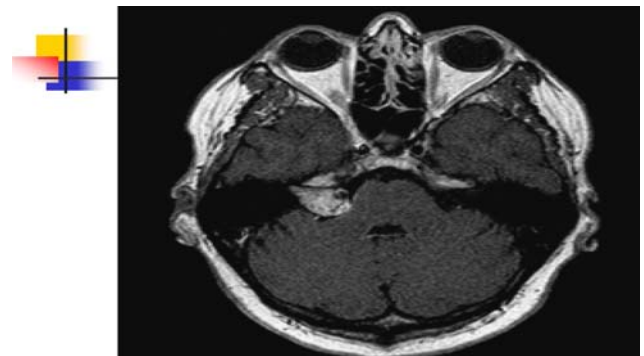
MRI has shown 18 × 16 mm lesion in the right internal acoustic meatus displacing the cerebellum and pons
